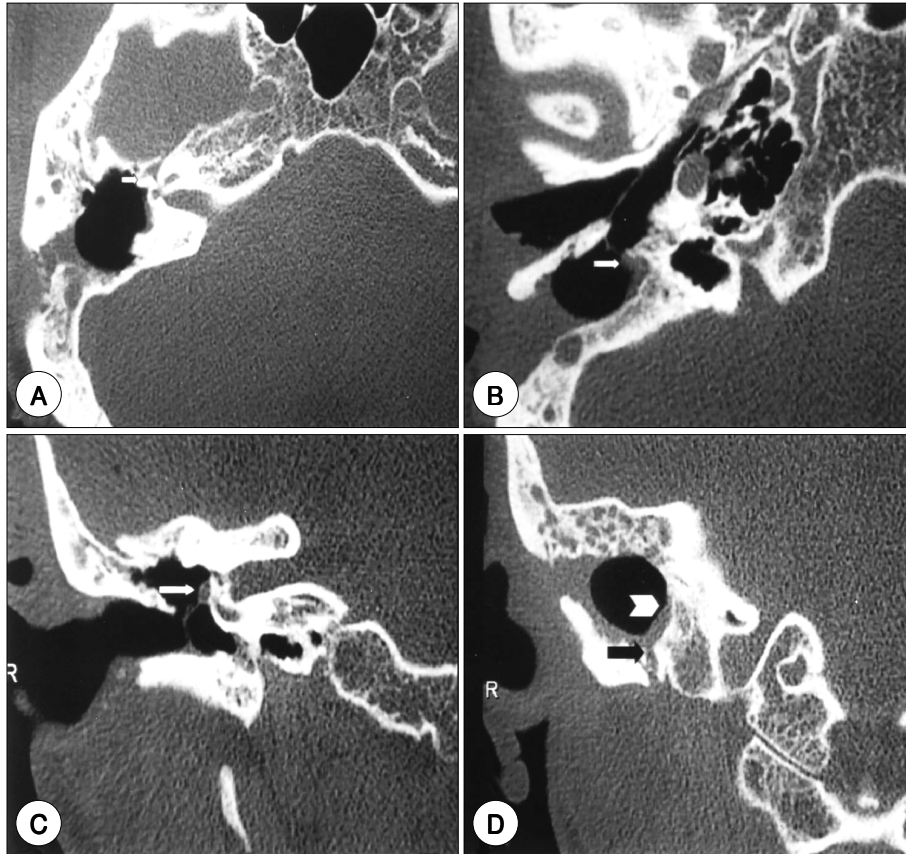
The temporal bone computed tomography (CT) eight months after nerve graft. A : Axial CT shows right geniculate ganglion (arrow). B : Axial CT reveals greater auricular nerve graft (arrow). C : Coronal CT shows decompressed horizontal segment of facial nerve (arrow). D : Coronal CT shows nerve graft (arrowhead) toward stylomastoid foramen (arrow).
